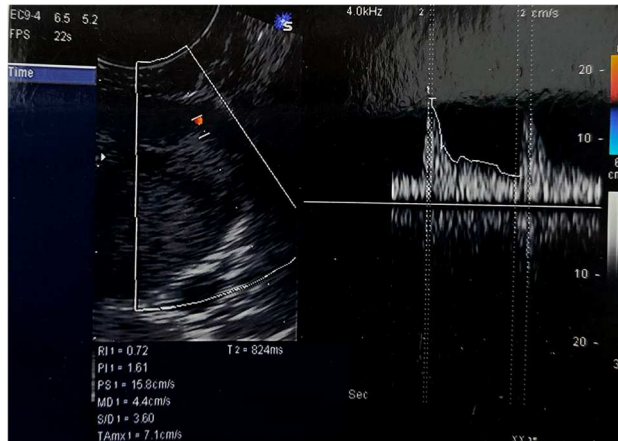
Ultrasound colour flow angiography of the prostate gland of a 30-year-old man (control group).
